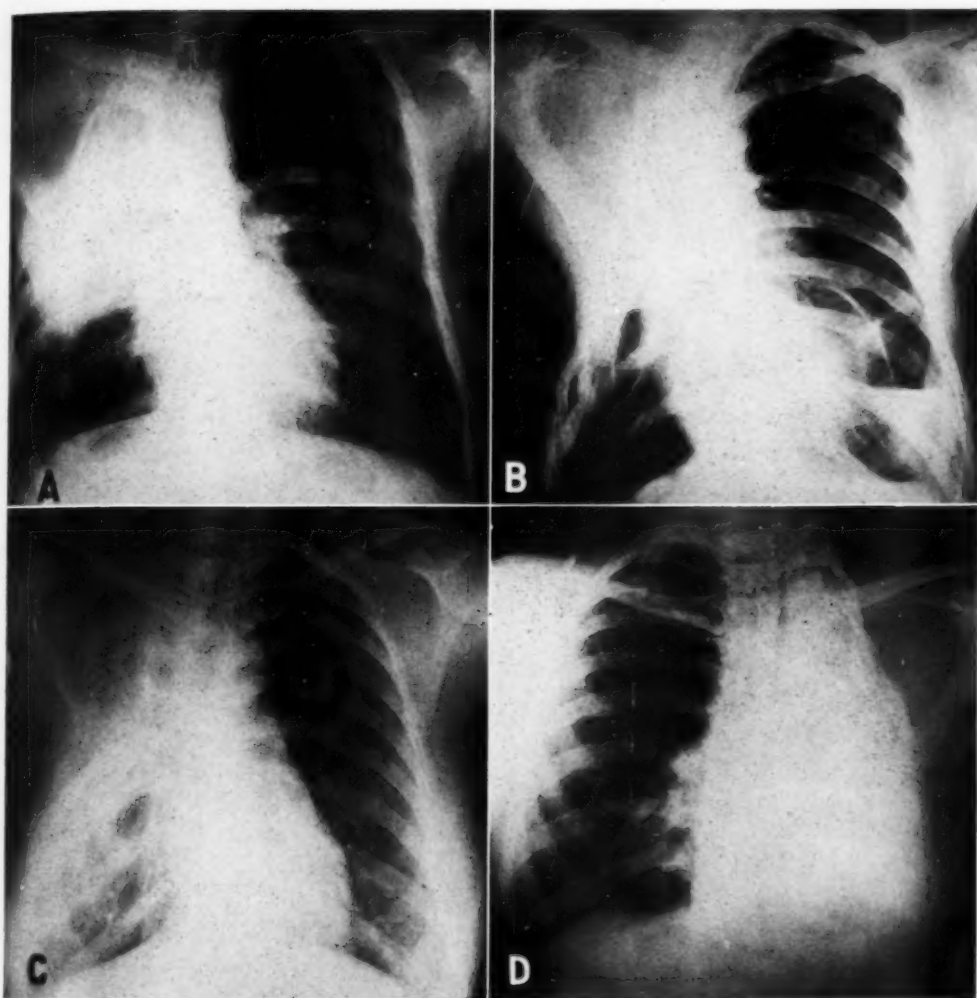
A. Post-thoracoplasty roentgenogram showing "localized lateral convexity" and annular shadow. There is also an effective contralateral pneumothorax; sputum positive. B. Roentgenogram of same patient following revision operation of upper thoracoplasty and additional rib resection. Localized lateral convexity absent; sputum negative. C. Roentgenogram following modern thoracoplasty (Semb type) showing ideal selective collapse; sputum negative. D. Roentgenogram following resection of short rib segments (Sauerbruch type) over dense fibrotic lung; sputum negative.
